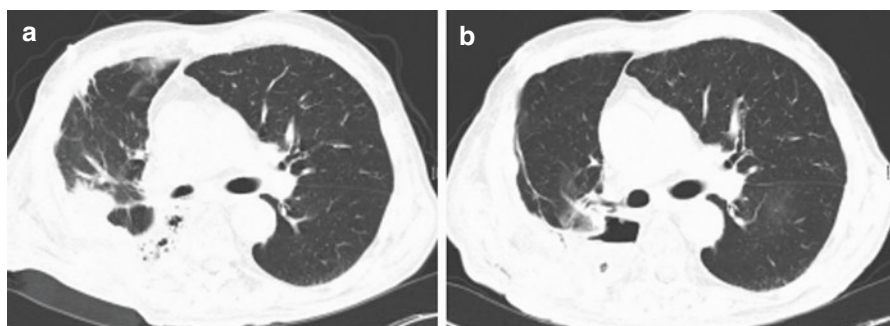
CT scan view of a patient with empyema after lung resection (a–b)
